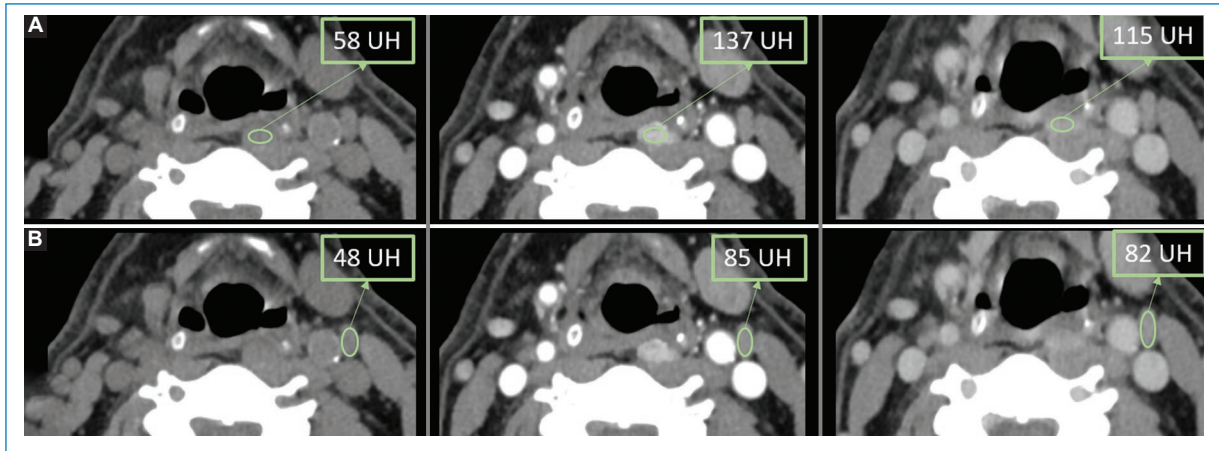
Comparison of the behavior in dynamic ultrasound of a parathyroid adenoma (A) and a lymph node (B) in non-contrast arterial and venous phases, from left to right, respectively. An adenoma shows intense enhancement in the arterial phase and washout in the venous phase, unlike the lymph node, which exhibits less enhancement in the arterial phase with no significant change in the venous phase.
